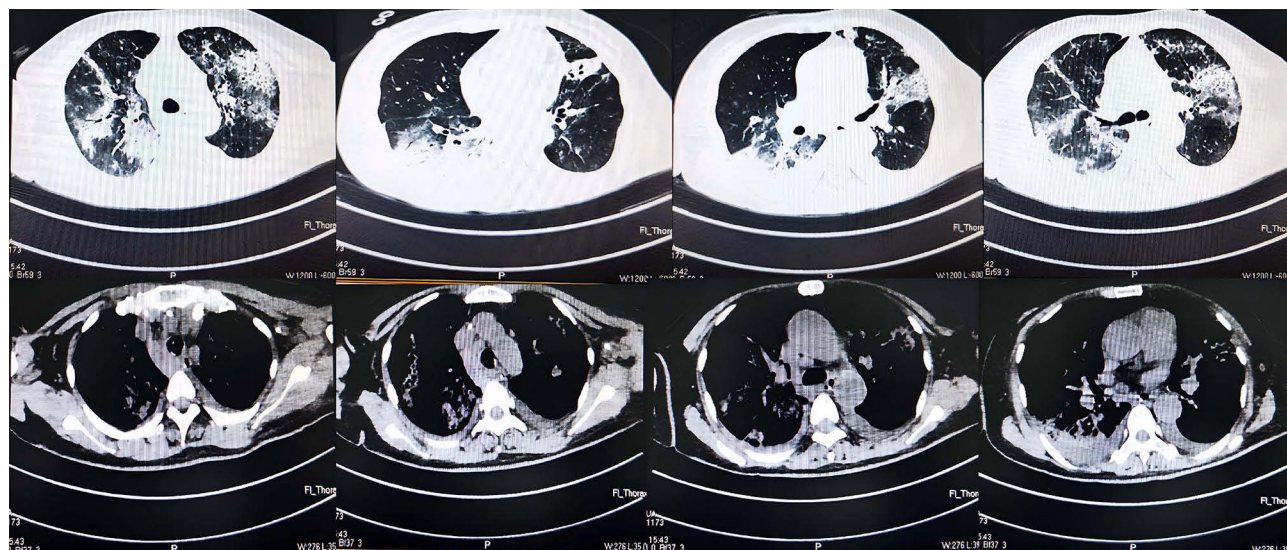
Multiple glass opacities and consolidation shadows were found in both lungs (CT image of the chest on the 7th day of admission).
